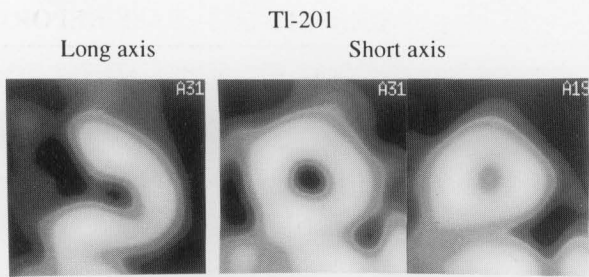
Rest TI-201 SPECT imaging shows no perfusion abnormality.
